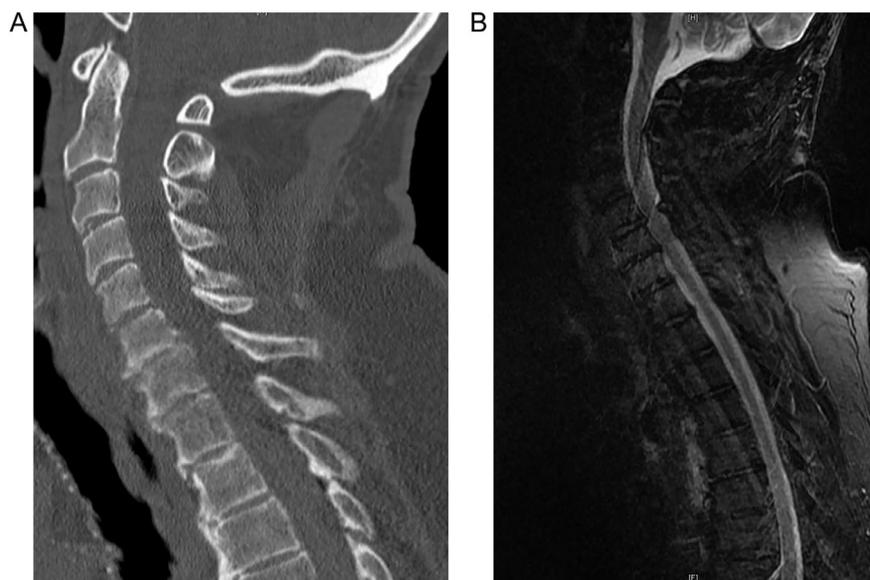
(A) No findings in Cervical CT of acute fracture or displacement. (B) MRI Spine: small edema in the C5/6 anterior disc space extending anteriorly between C5 and C7 suspicious for extension injury.
